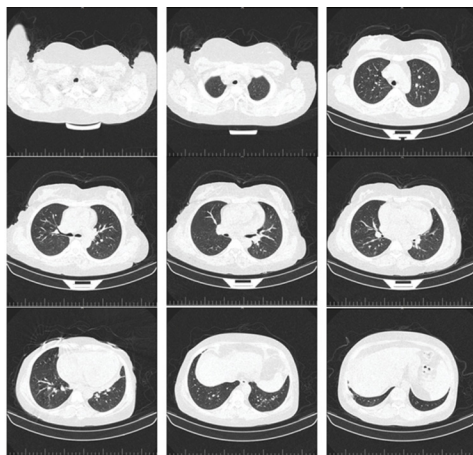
Chest CT-scan after treatment.
